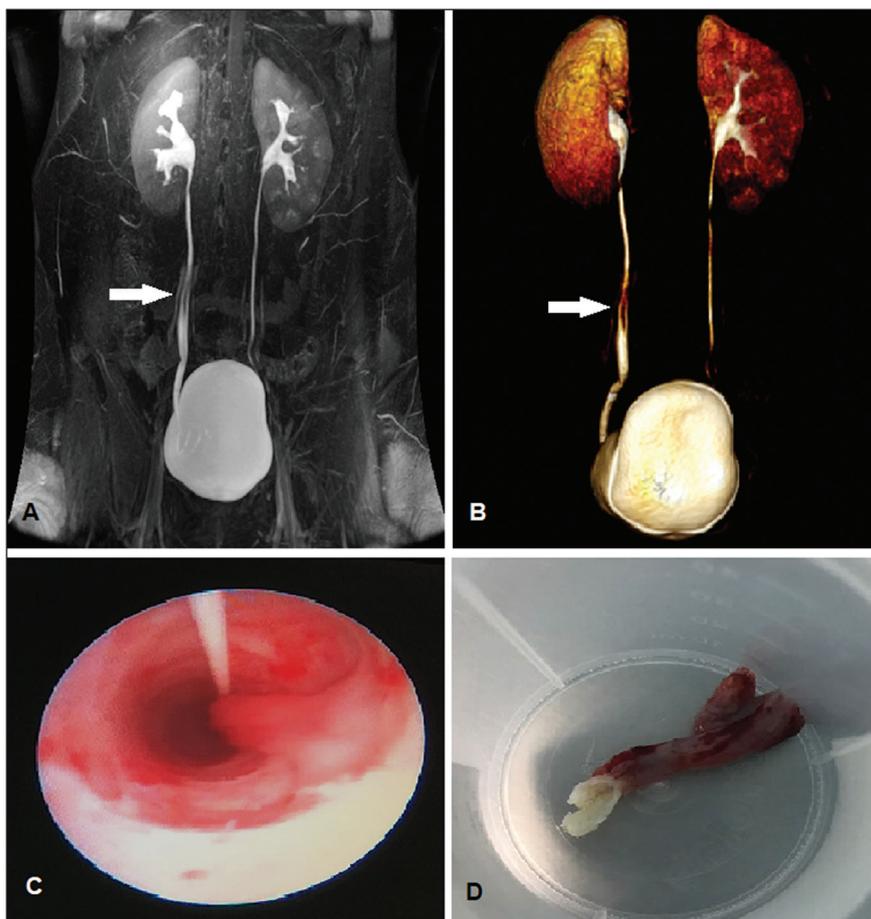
Coronal magnetic resonance imaging of the urinary tract (A) and three-dimensional reconstruction (B), showing an elongated polypoid formation with a probable origin in the middle ureter (arrow). C: Ureteroscopy showing an intraluminal polyp. D: Macroscopic aspect of the lesion.
